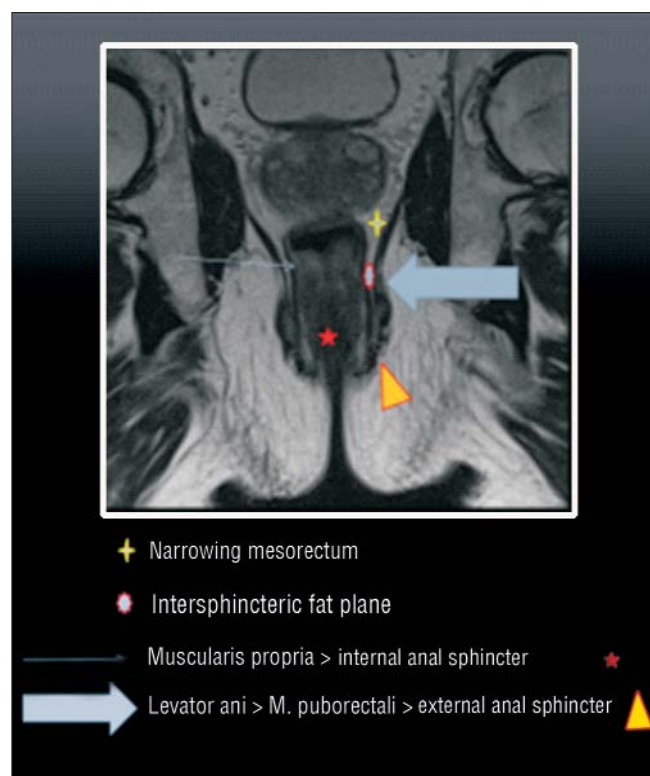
T2-weighted coronal oblique MRI. The normal anatomy of the anorectal complex can be observed. Observe the fat intersphincteric plane (red circle) and the external sphincter (blue arrow) representing the continuation of the low portion of the anal levator and puborectalis muscles. The black strip (thin blue arrow), namely the muscularis propria passes in the internal anal sphincter (red star).
